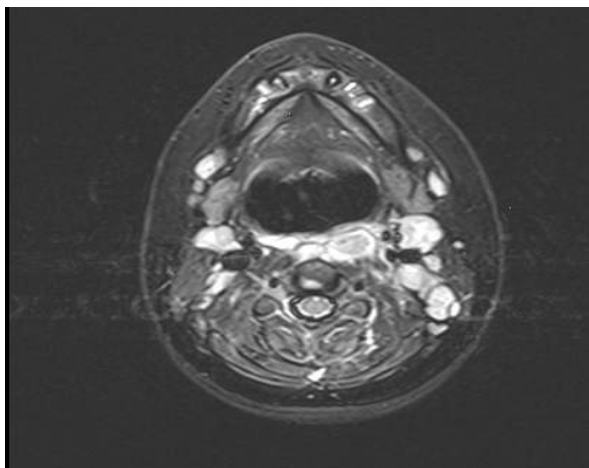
MRI - T1 weight axial scan: the abscess involved the left side of the retropharyngeal space.
